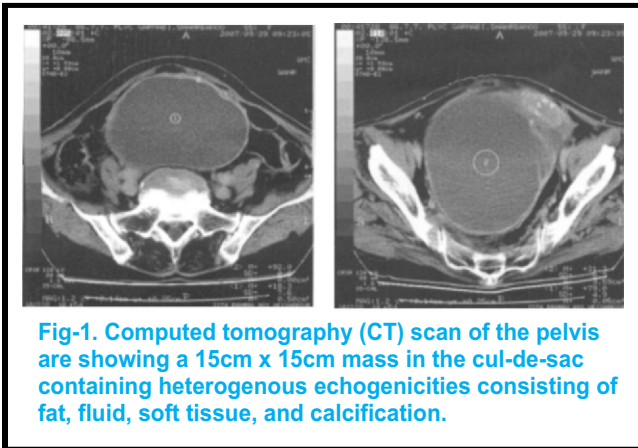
Computed tomography (CT) scan of the pelvis are showing a 15cm x 15cm mass in the cul-de-sac containing heterogenous echogenicities consisting of fat, fluid, soft tissue, and calcification.
